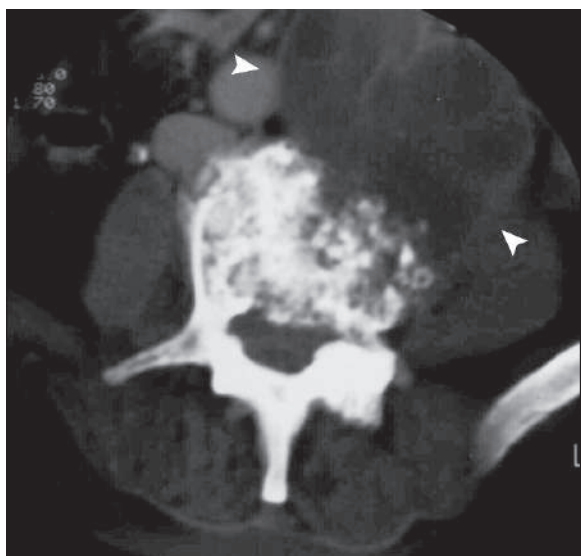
Axial nonenhanced vertebral CT shows vertebral destruction in a patient with Pott's disease, with left paraspinous cold abscess formation (*arrowheads*)
